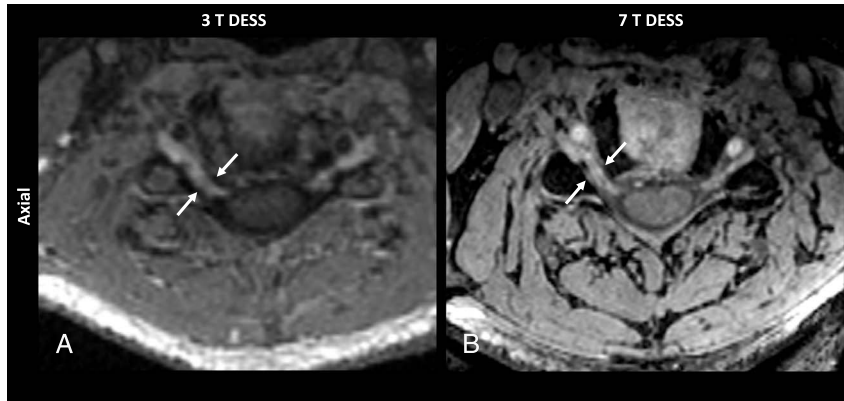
Axial reformations of a 3D DESS sequence of a patient with symptomatic cervical radiculopathy at the level of the right C5 nerve root, acquired at 3 T MRI (A) and 7 T MRI (B). Note the increased spatial resolution with better visualization of the cervical nerve root at 7 T MRI compared with 3 T MRI (arrows).
